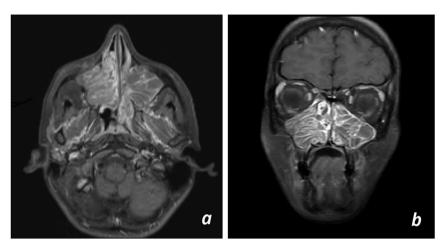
Magnetic resonance imaging (MRI) findings of two independent oncocytic papillom show typical cerebriform pattern. a. T1 axial section. b. T1 coronal section.
